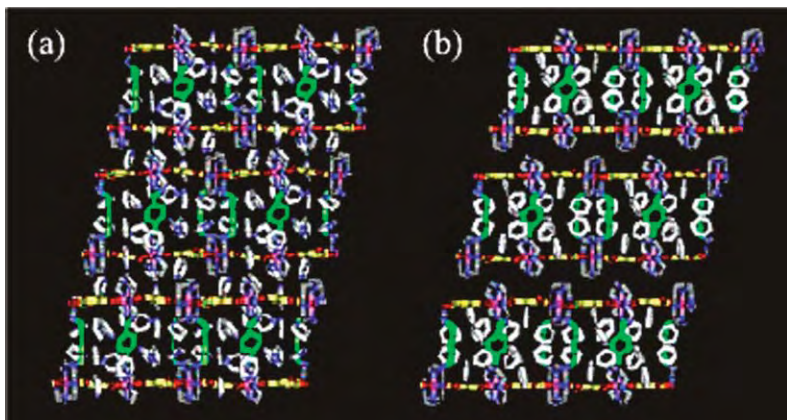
X-ray structures (side views) of (a) 13-3 and (b) 13-4. Organic guest inclusions are indicated as off-white, and water guest molecules are omitted for clarity.
